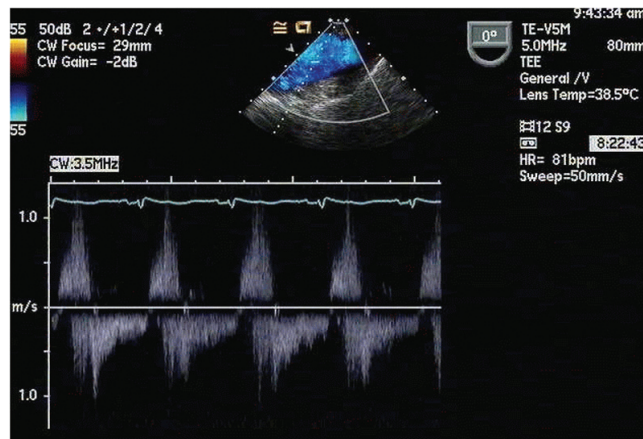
Infected prosthetic aortic valve regurgitation. Trans-esophageal echocardiography was helpful in identification of the prosthetic valve infection and dysfunction.
